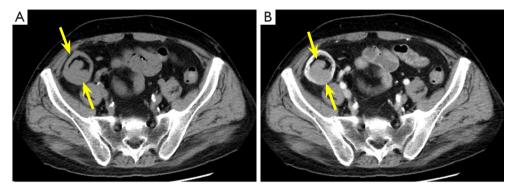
CE-CTU imaging confirming the solid mass. (A) The plain scan revealed an irregular occupying lesion in the lower pole of the atrophic kidney graft, involving the parenchyma and collecting system. (B) The enhanced scan showed mild enhancement of the solid mass. The yellow arrows indicate the location of the lesion, CE-CTU, contrast-enhanced computed tomography urography.
